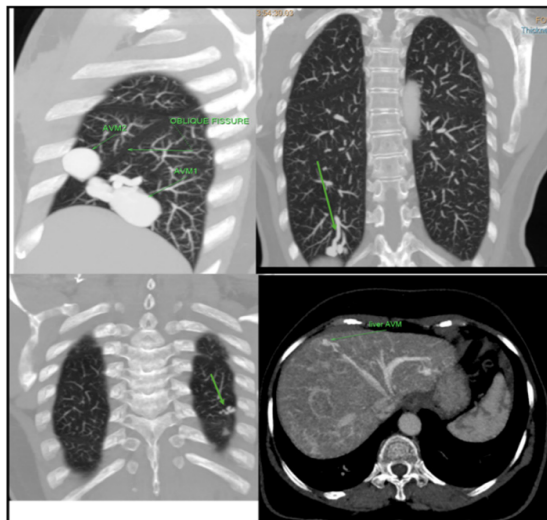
(A):- Reconstructed CT
